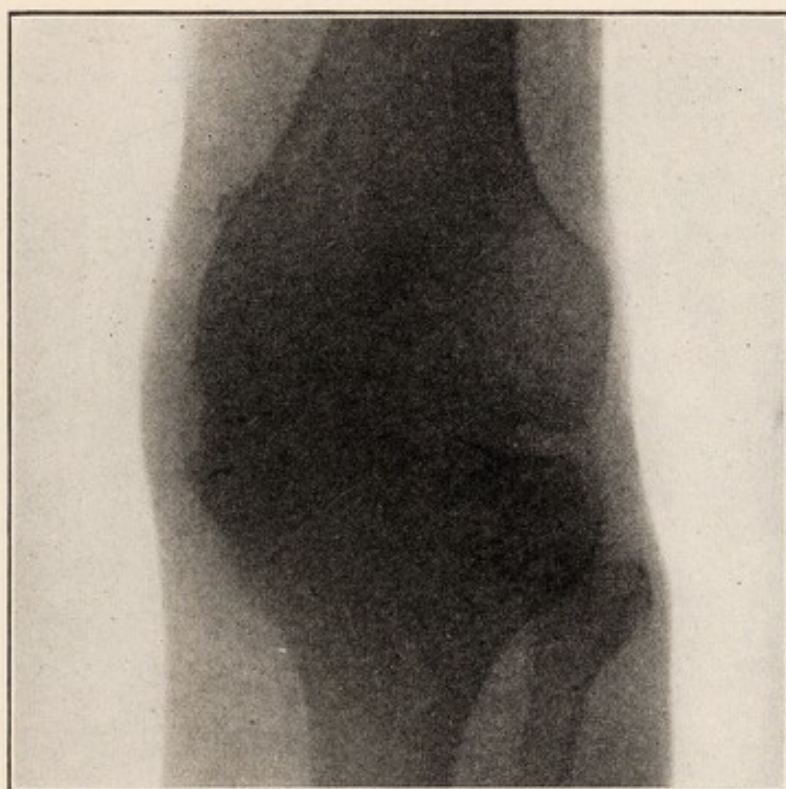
X-ray of Case IV tuberculous ankylosis right knee before operation.
